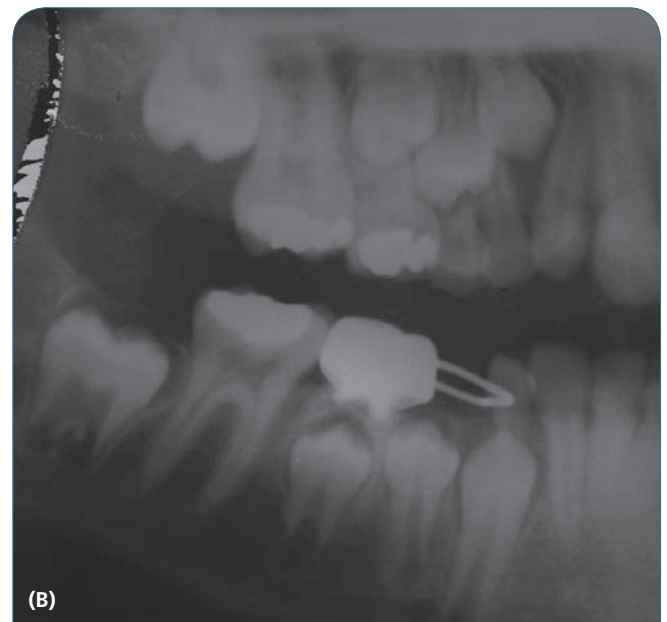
(A) Fixed bilateral space maintainer. (Courtesy of Dr. Steven E. Gregg.) (B) X-ray of patient with a fixed unilateral space maintainer.
